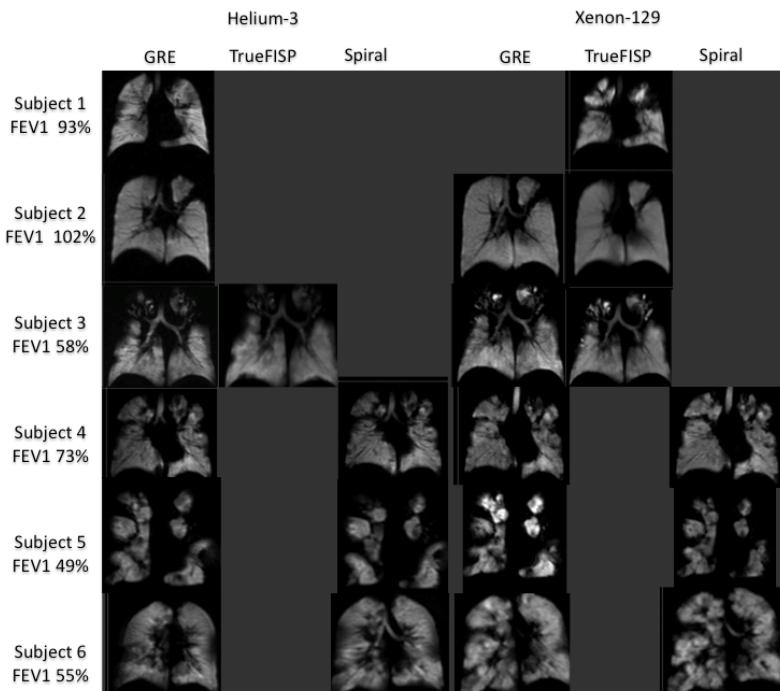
Coronal HHe and HXe MR images from 6 subjects with CF. Most subjects have ventilation defect in similar locations on both HHe and HXe MRI; however, there are some differences in the appearance of both the defects and the more normally ventilated lung in some subjects. In particular, Subjects 1 and 6 have more conspicuous and larger defects on HXe. Subjects 2 and 4 have nearly identical defects on HHe and HXe. Subjects 3 and 5 have similar appearing defects but there are focal areas of hyper-intense signal with HXe not as apparent with HHe.
